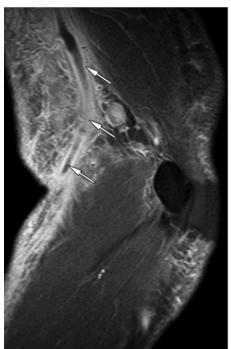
Septic thrombophlebitis in a 22-yearold man with a history of intravenous drug use and elbow pain. (a) Axial fat-saturated proton densityweighted MR image shows subcutaneous soft-tissue edema at the anterior, medial, and posterior aspects of the distal arm. There is also edema centered about the basilic vein (arrow) with edema tracking along the deep fascia (arrowhead). (b, c) Axial (b) and sagittal oblique (c) T1-weighted fat-saturated postcontrast images show a long-segment filling defect in the basilic vein (arrows) with perivenous soft-tissue enhancement also extending along the deep fascia (arrowhead). Subsequent US (not shown) of the upper extremity demonstrated occlusive basilic vein thrombosis. These findings are consistent with septic thrombophlebitis (ie, superficial venous thrombosis and accompanying adjacent soft-tissue infection).
